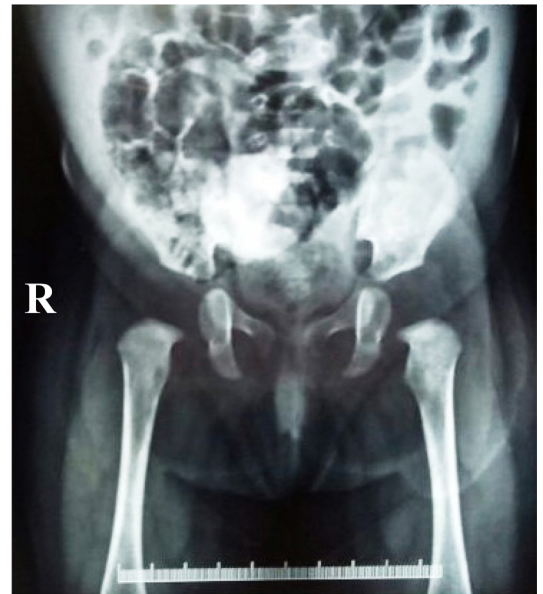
Cystogram (radiograph of the bladder with contrast, not properly visualized as not holding the contrast). R, right.
